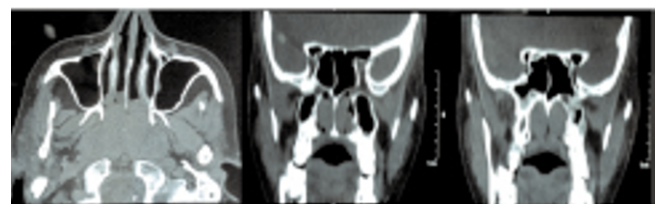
CT scan PNS showing well defined soft tissue nasopharyngeal mass (3.8 cm×2.7 cm×4.0 cm) extending up to the choanae bilaterally without bony erosion.
